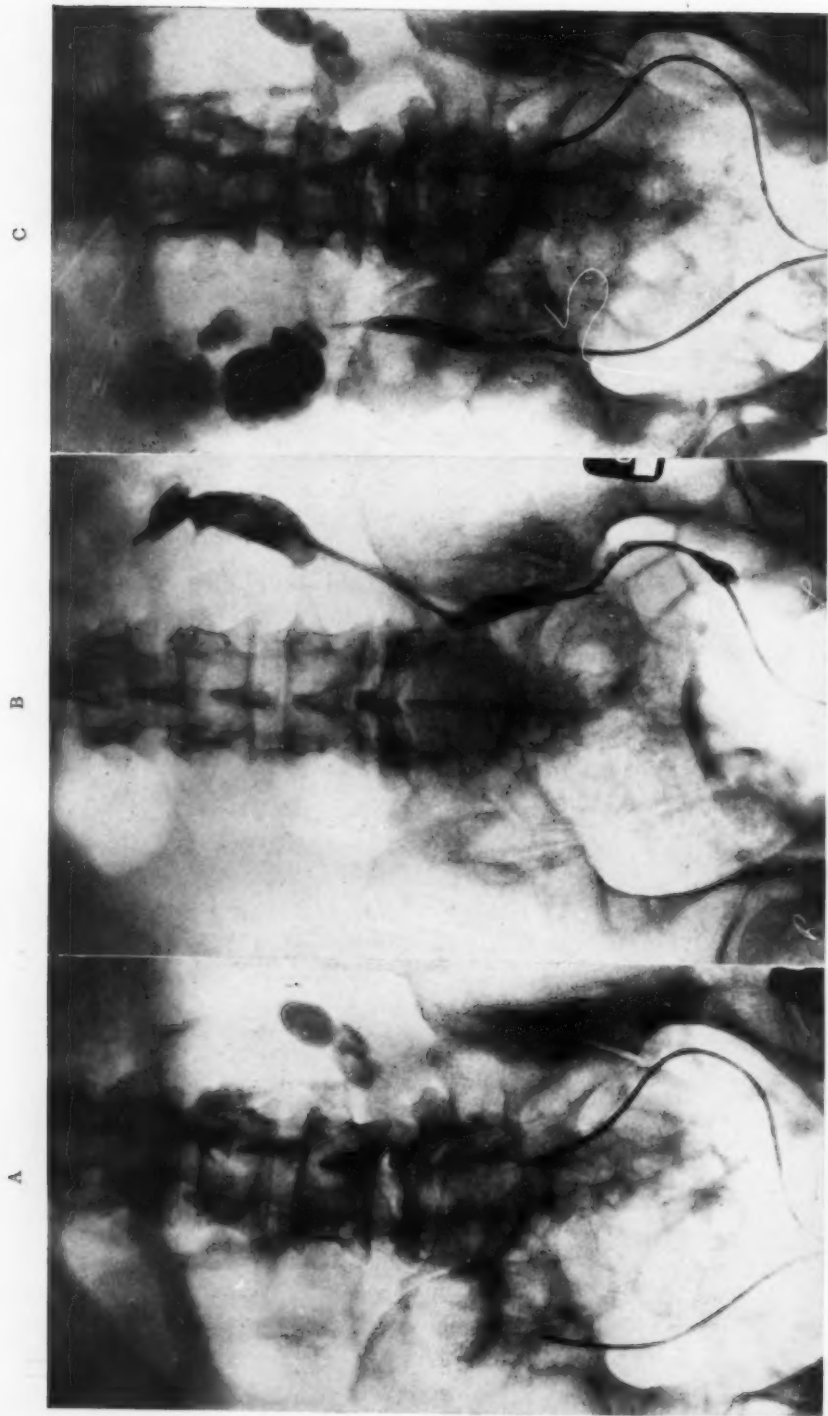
Radiographic and pyelographic findings in Case II. A. Shadows of the four calyces arranged in serial manner obliquely opposite fourth lumbar vertebra. B. Pyelogram including shadows seen in A, with several calyces directed mesially. Note peculiar shape of this pelvis. C. Pyelogram of right half showing marked dilatation of pelvis and calyces (infected hydronephrosis).
